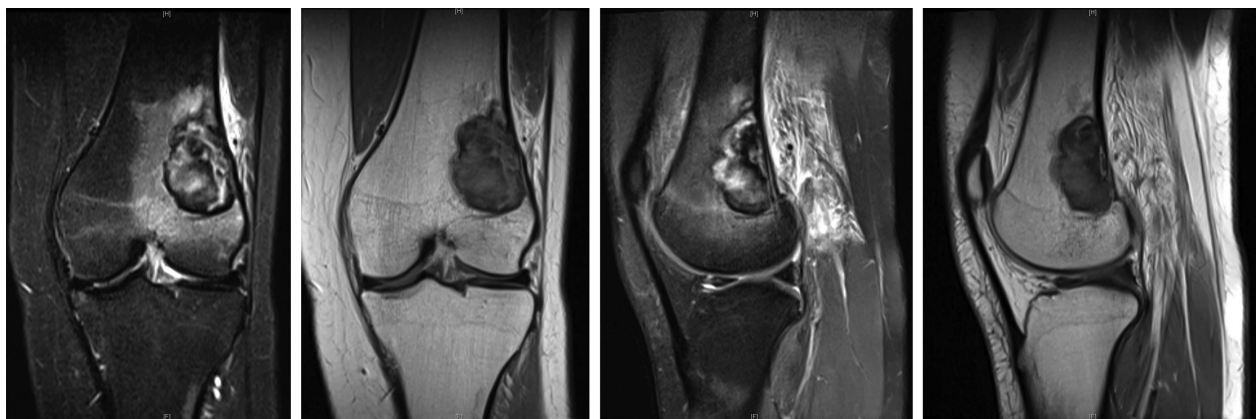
Magnetic resonance imaging—coronal T2 + fatsat, coronal T1, sagittal T2 + fatsat, sagittal T1. Again note an eccentric lesion of the distal femur with a narrow zone of transition. There is no associated periosteal reaction. The characteristic low signal on both T1- and T2-weighted images is consistent with nonossifying fibroma. Some interspersed high signal with associated soft-tissue edema is consistent with a stress fracture and muscular strain associated with the patient's history of distance running.
